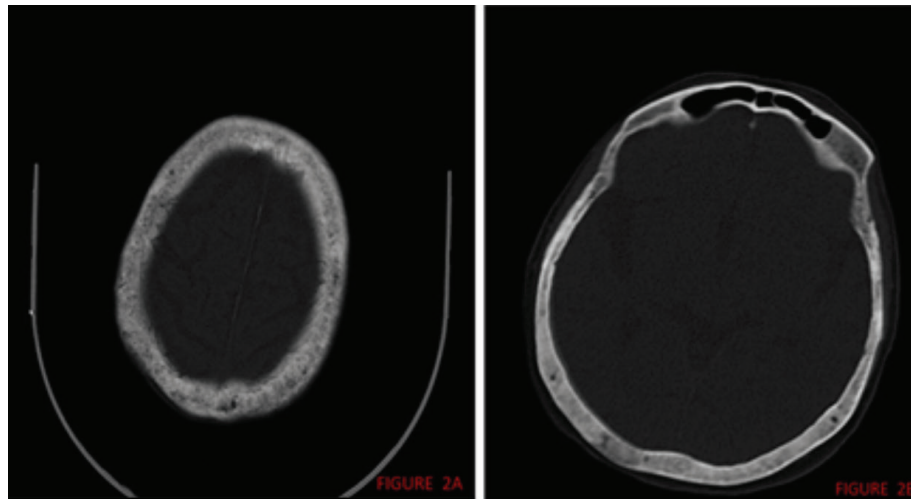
Cranial CT before treatment, Figure 2B. Cranial CT after treatment
